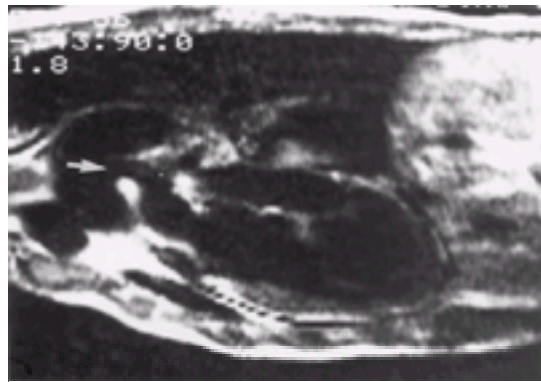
Magnetic resonance imaging in a sagittal–coronal view showing a patent ductus arteriosus (arrow) in an adult.
